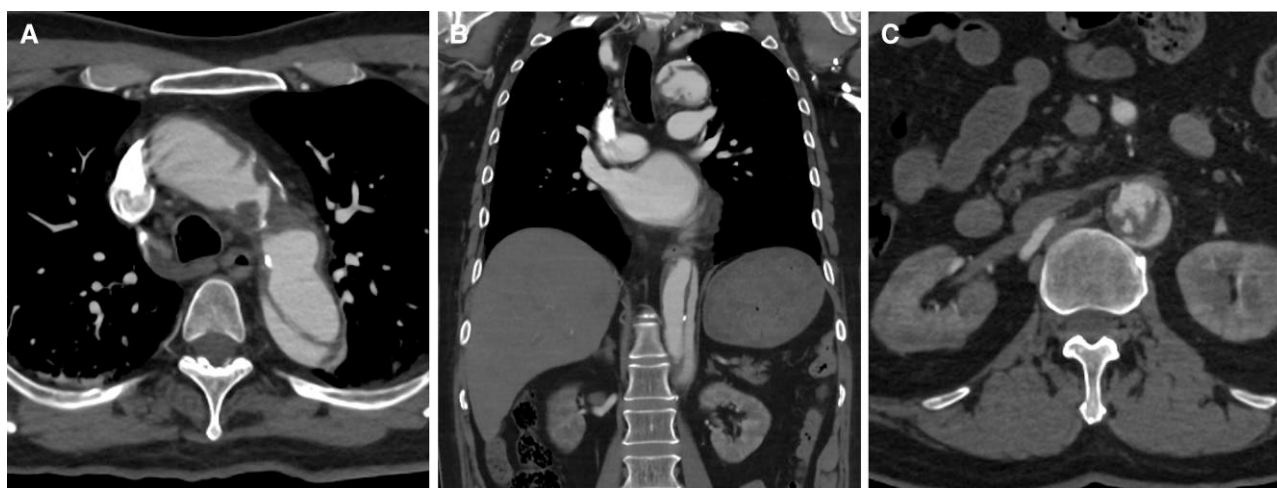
Arterial phase contrast-enhanced computed tomography of type B aortic dissection with a patent false lumen from the distal aortic arch to the abdominal aorta. (A) Axial view of the thorax showing vulnerable and irregular plaque along the aortic wall. (B) Coronal view. (C) Axial view of the abdomen showing heterogeneous contrast-impaired areas in the bilateral kidneys.
